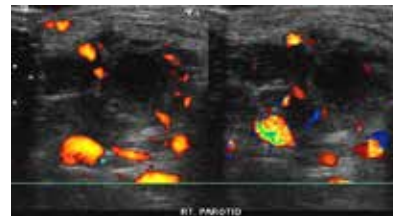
Parotid abscess: Ultrasound and Power Doppler / Color Doppler images reveal: a) Marked swelling of the right parotid gland b) multiple anechoic and hypoechoic cystic spaces within the right parotid gland c) marked augmentation of vascularity in the right parotid gland.
